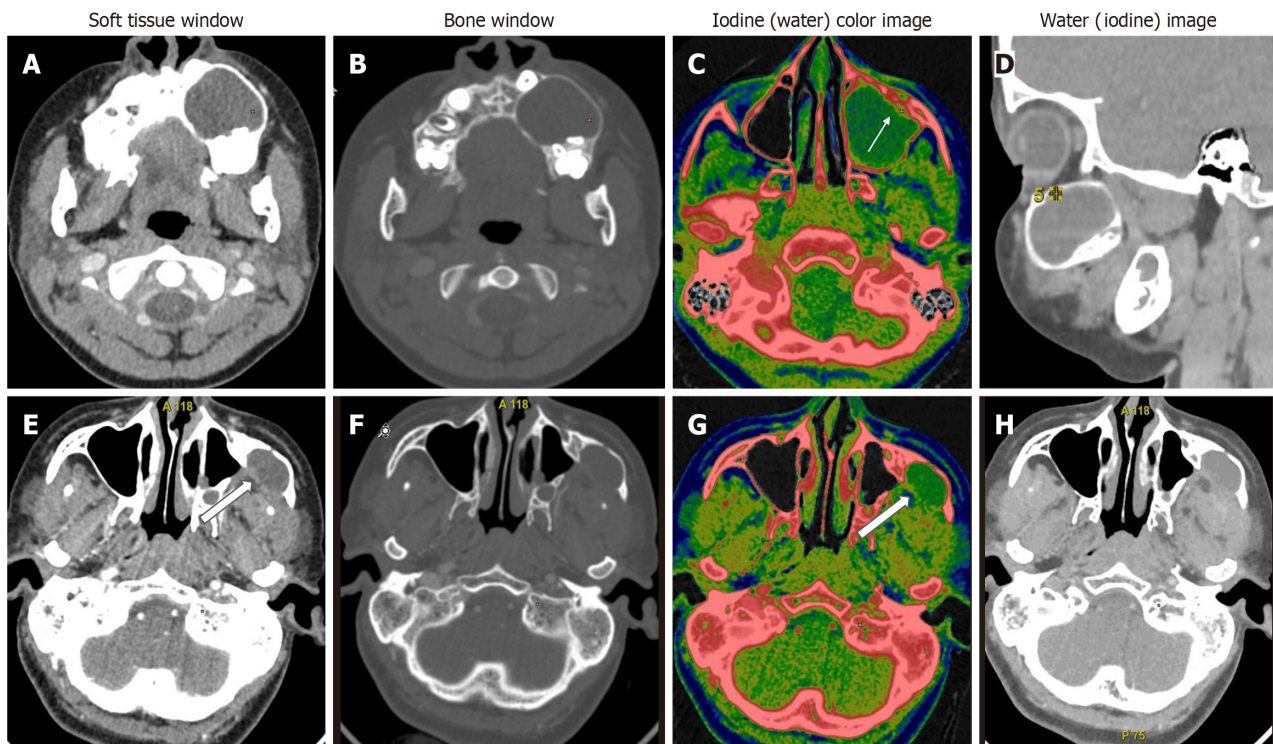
Unilocular lytic lesions differentiated based on water concentration. A-D: Unilocular ameloblastoma - contrast-enhanced dual-energy computed tomography images show a well-defined lytic unilocular cystic, expansile lesion in the left maxilla with mild peripheral rim enhancement better appreciated on iodine colour overlay images (white arrow). Water (iodine) material decomposition (MD) images showed a WC of $986 \mu\text{g}/\text{cm}^3$ in the cystic component; E-H: Odontogenic keratocyst is also a well-defined lytic, unilocular cystic, expansile lesion in the left lateral wall of the maxillary sinus with a small enhancing mural component posteriorly (white open arrows). Water (iodine) MD images revealed a water concentration of $1045 \mu\text{g}/\text{cm}^3$ in the cystic component. In this case, due to the paucity of soft tissue components, iodine concentration did not help; however, the water concentration of the cystic component differed significantly, aiding in the diagnosis.
